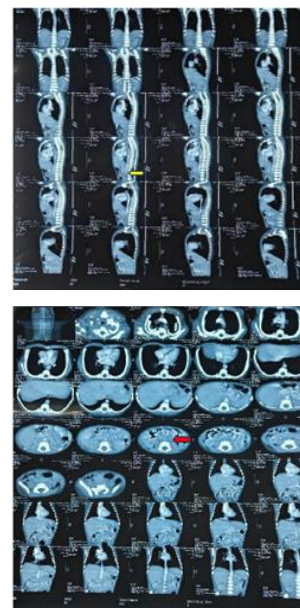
The abdominal CT angiography
